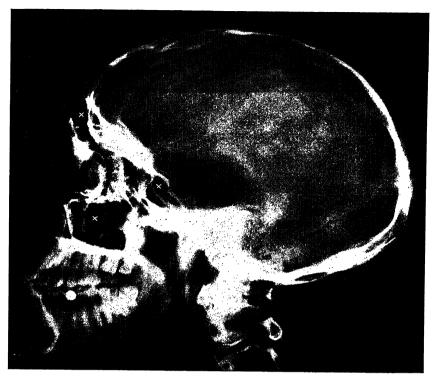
Radiograph of skull. Lateral view. Crosses are placed on the frontal, the maxillary and the sphenoidal sinuses. Behind the last-named, the hypophyseal fossa can be identified. The dense white area below and behind the fossa is due to the petrous part of the temporal bone.
